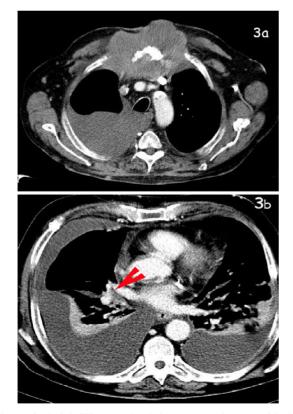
Axial CT scan. (a) A large sternal mass with destructive pattern and involvement of soft tissue associated with bilateral pleural efussion; (b) Endobronchial lesion at the origin of the middle lobe bronchus caused by hypodense mass which is compatible with neoplastic process (red arrow).
